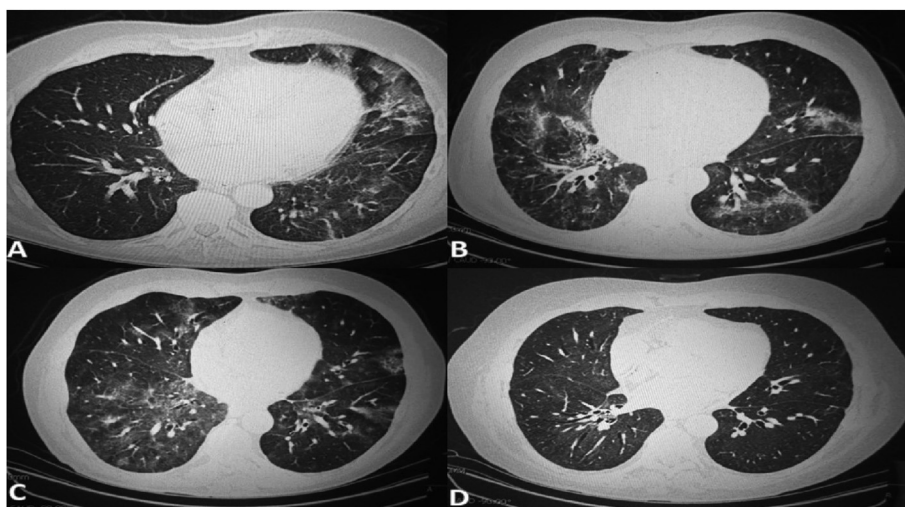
Chest CTs of a 63-year-old male (Case 4). A. CT shows multifocal ground glass opacities concentrated on the left side of a two months after his first positive SARS-CoV-2 test. B. CT shows persistent findings two months after receiving a prednisone taper. C. CT chest scan after repeat steroid taper show reveals persistent bilateral multifocal ground glass opacities. D. CT after two doses of intravenous immune globulin shows markedly improved ground glass opacities.
